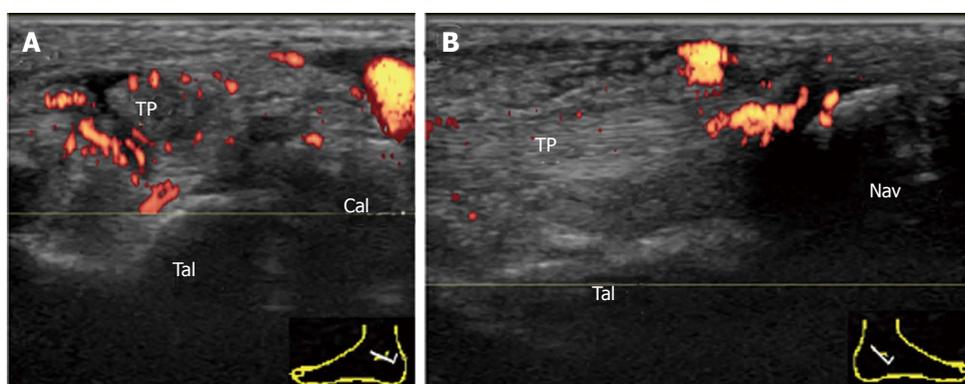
Involvement of the tibialis posterior tendon in systemic lupus erythematosus. A: Tenosynovitis of the TP in systemic lupus erythematosus. Transverse power Doppler sonogram over the inframalleolar area shows thickening and hyperemia of the tendon sheath with small synovial effusion; B: Enthesitis of the contralateral TP in the same patient. Longitudinal power Doppler sonogram of the TP shows intratendinous hyperemia adjacent to the insertion into the navicular bone. Tal: Talus; Cal: Calcaneus; TP: Tibialis posterior; Nav: Navicular bone.
